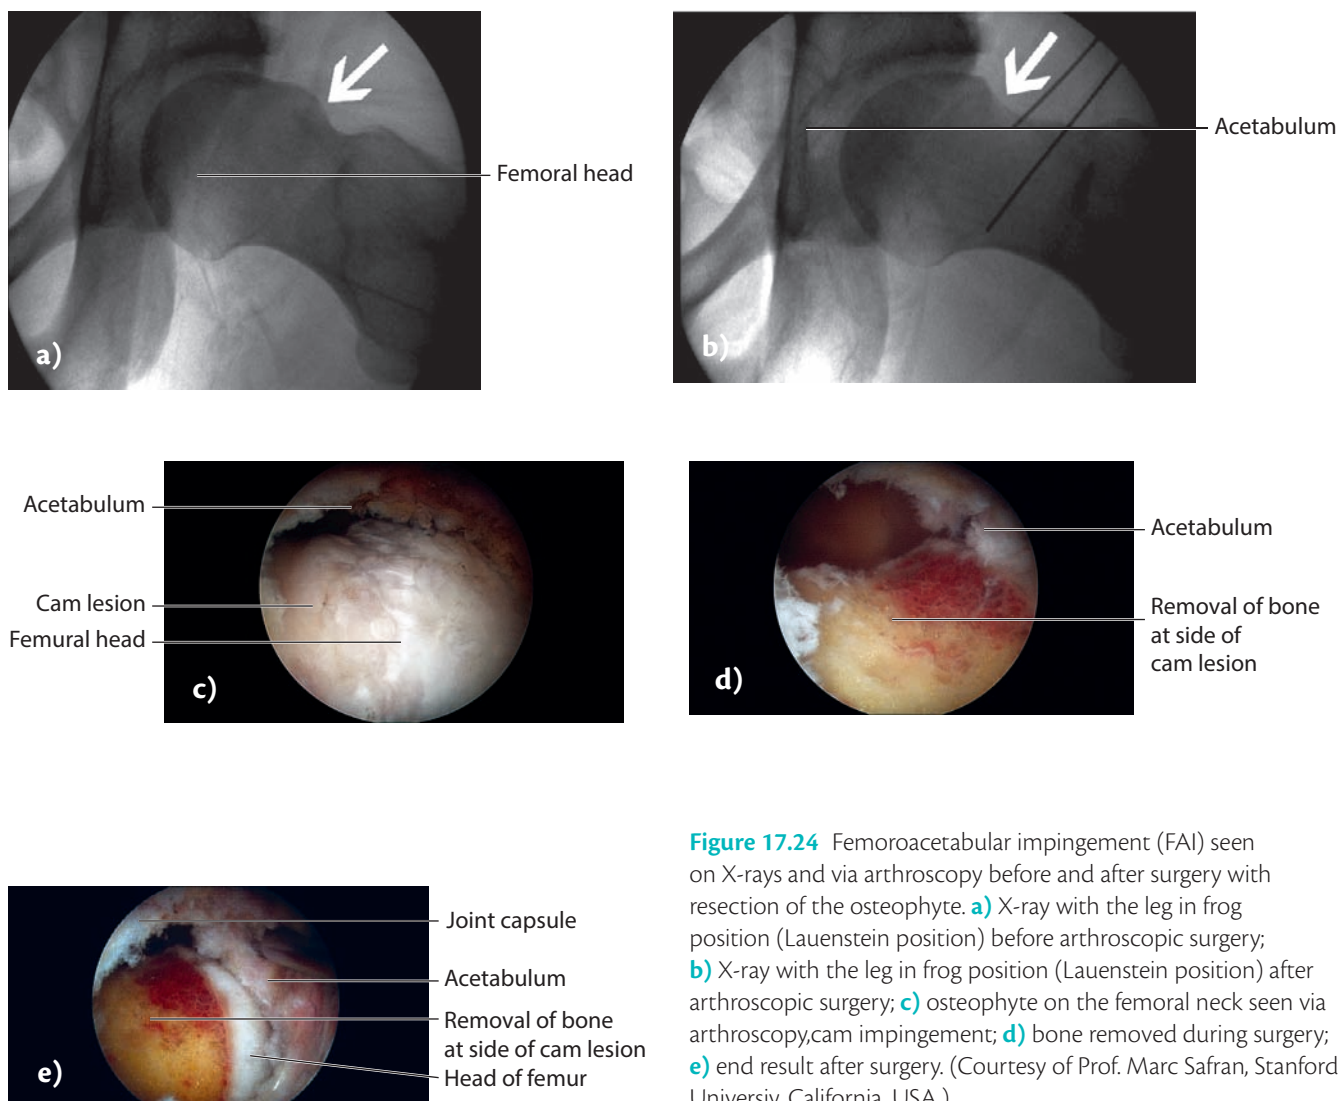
Femoroacetabular impingement (FAI) seen on X-rays and via arthroscopy before and after surgery with resection of the osteophyte. a) X-ray with the leg in frog position (Lauenstein position) before arthroscopic surgery; b) X-ray with the leg in frog position (Lauenstein position) after arthroscopic surgery; c) osteophyte on the femoral neck seen via arthroscopy, cam impingement; d) bone removed during surgery; e) end result after surgery. (Courtesy of Prof. Marc Safran, Stanford University, California, USA.)
